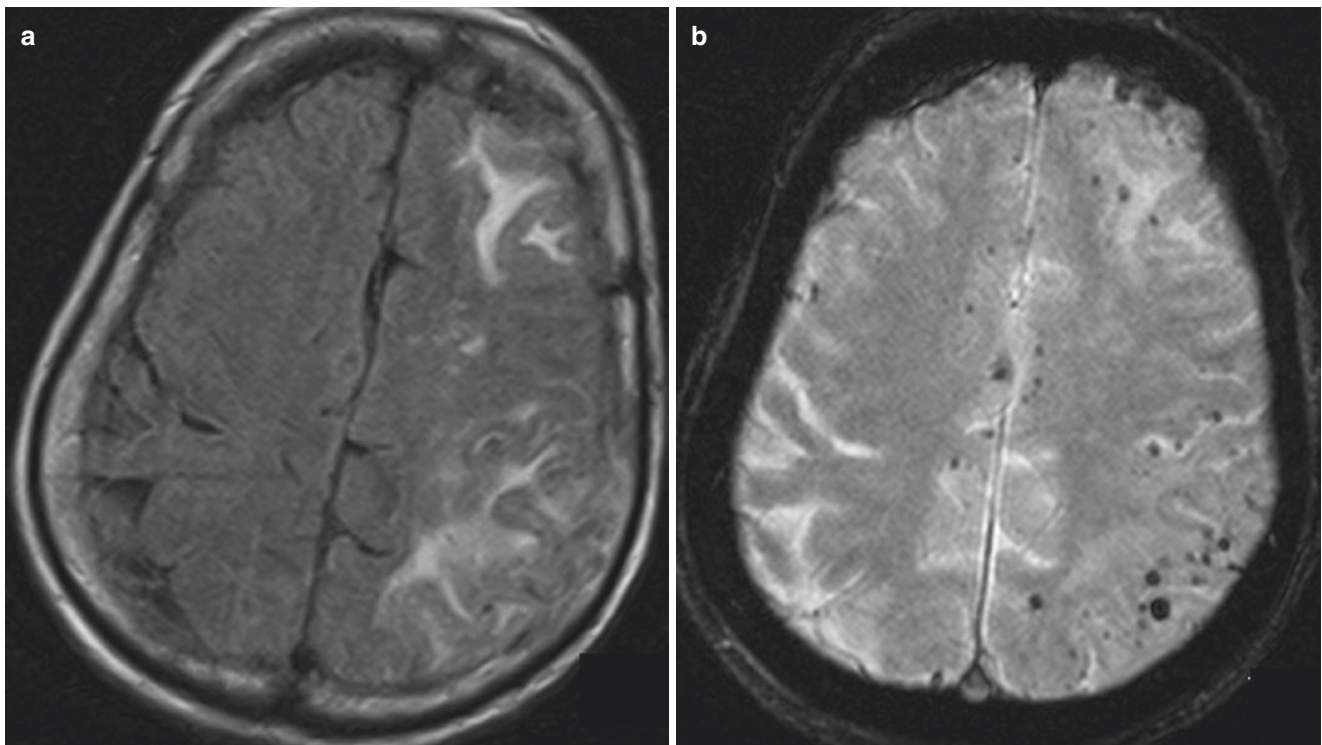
CAA-related inflammation. Patient presents with altered mental status and seizure. (a) FLAIR shows asymmetric vasogenic edema of the left cerebral hemisphere. (b) GRE sequence shows multiple lobar microbleeds from amyloid deposition
